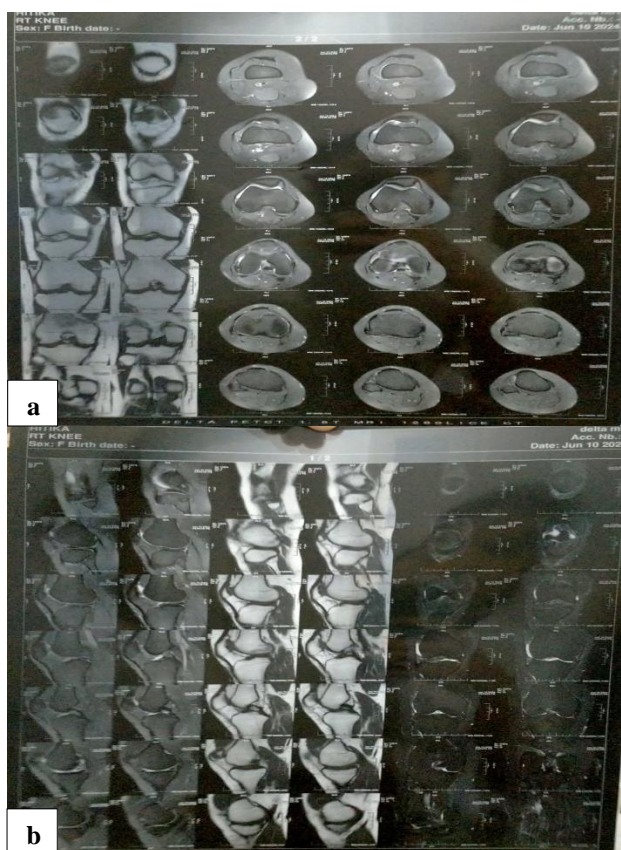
(a and b): Magnetic resonance imaging of patient's right knee.
